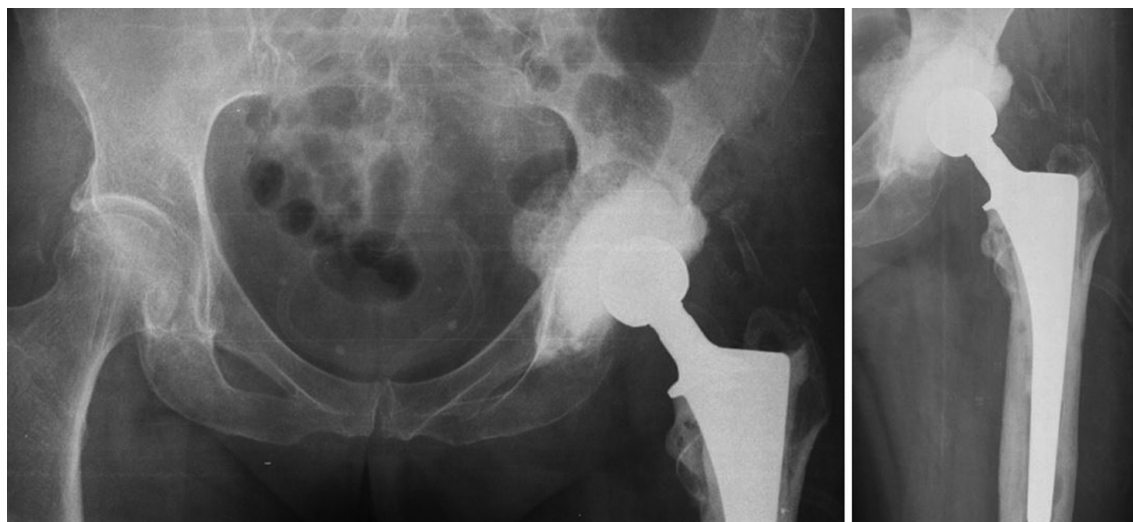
Radiographs of the pelvis and left hip joint one month after the operation
